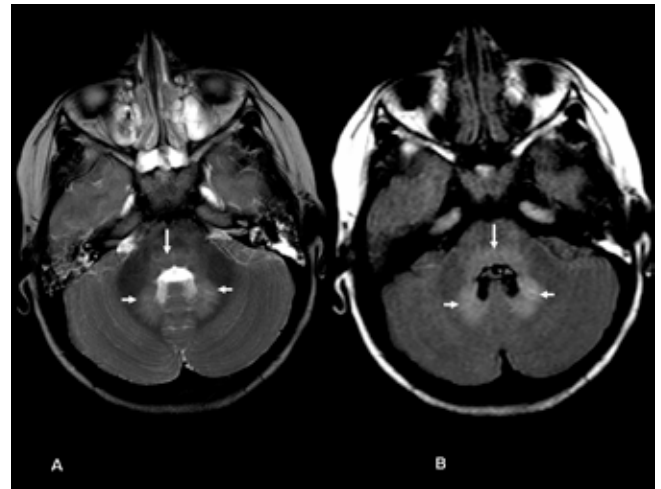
Axial T2-weighted and FLAIR images at the level of the pons show T2 hyperintensity within the pontine tegmentum (long arrows) and dentate nuclei bilaterally (short arrows).
